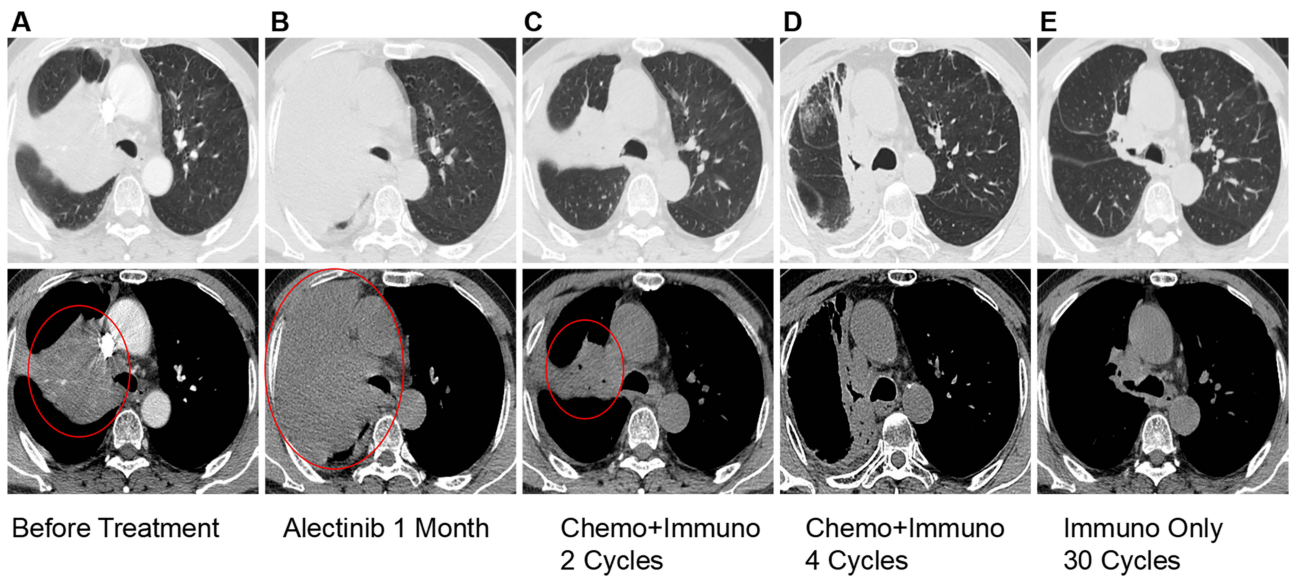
Computed tomography (CT) scans for the case. The chest CT showed changes in the primary lung carcinoma (indicated by red circles in A–C): (A) at baseline, (B) after one month with alectinib treatment, (C) after two cycles of chemoimmunotherapy, (D) after four cycles of chemoimmunotherapy, and (E) after thirty cycles of immunotherapy.
